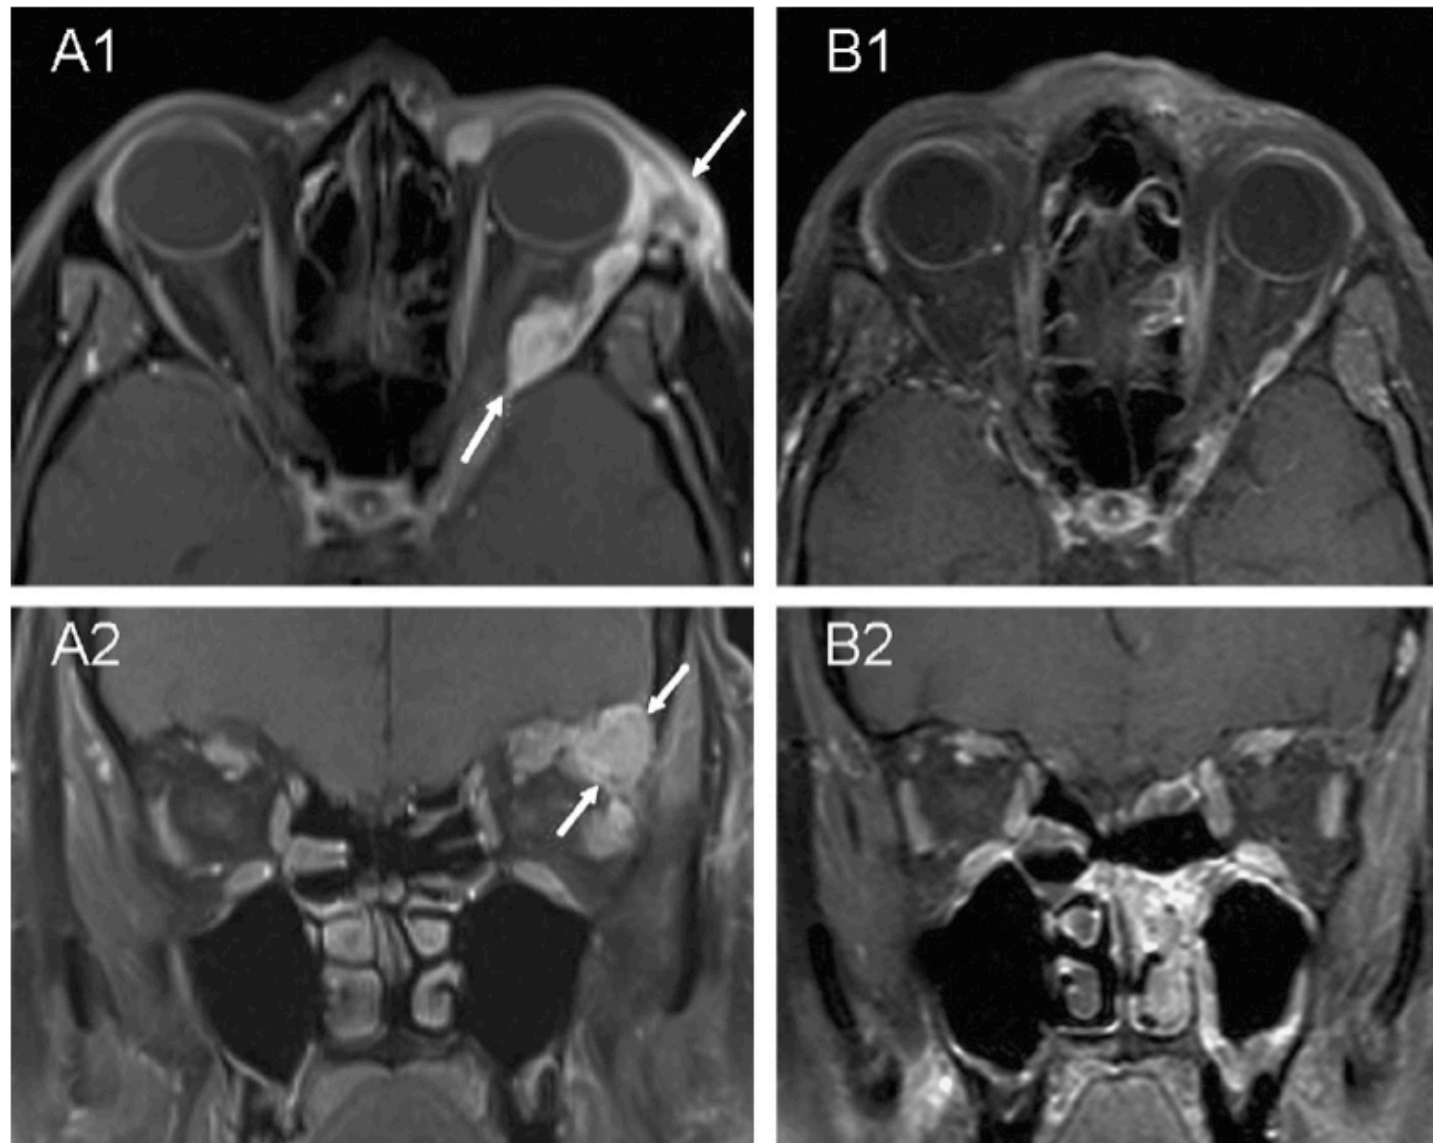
(A) Recurrent adenoid cystic carcinoma of lacrimal gland before BNCT shown in transverse (A1) and frontal (A2) MRI views. (B) Partial response after BNCT in transverse (B1) and frontal (B2) views. The arrows point at the tumor.
